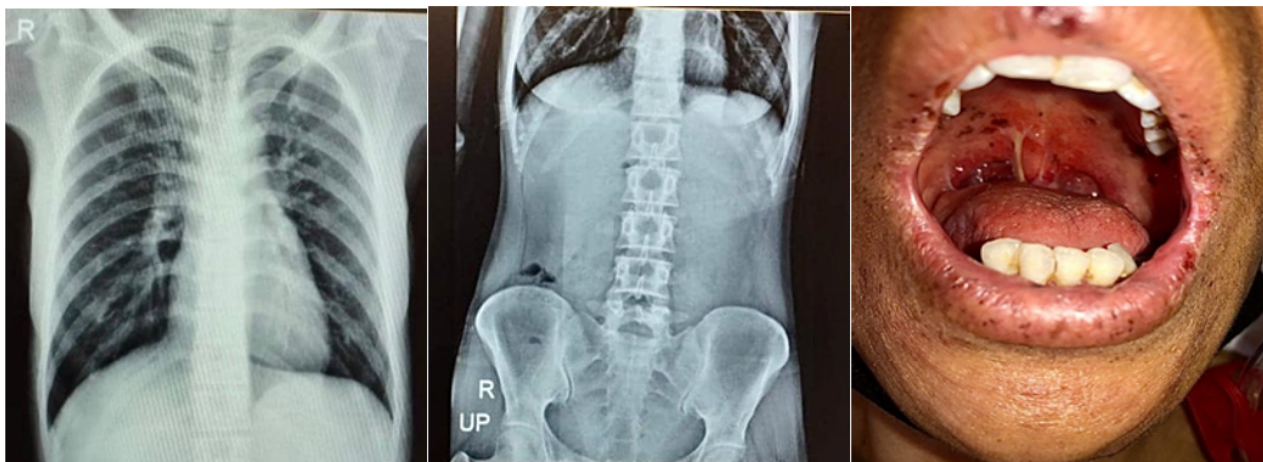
Upright chest X-Ray (left), upright abdominal X-Ray (middle), and patient's face (right)
